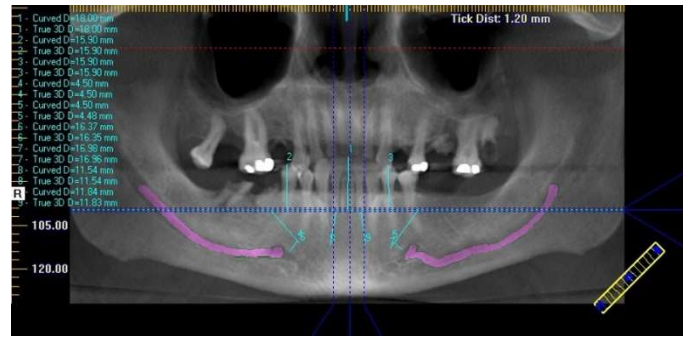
Proposed vertical level of the mandibular osteotomy as viewed on a reconstructed CBCT. IAN is highlighted in pink.
